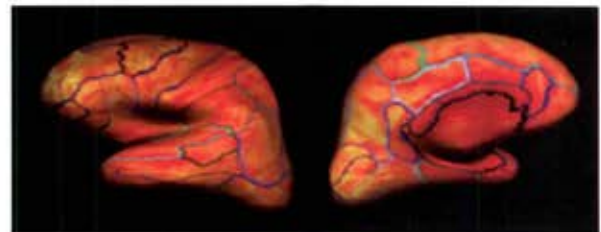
Lateral and medial views of raw FDG uptake mapped onto inflated brain. Parcellated cortical regions are outlined.
